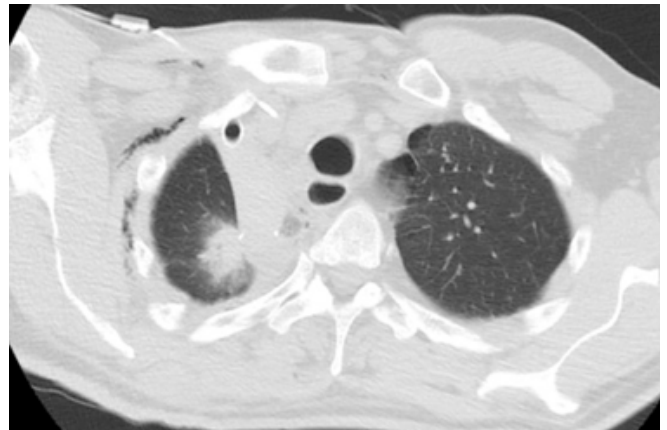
Postoperative thorax computed tomography of patient
